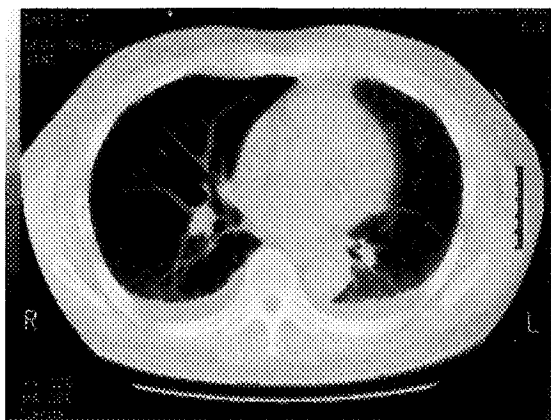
CT scan of the chest demonstrating bilateral pleural effusions and a non-specific parenchymal density at the left base.
